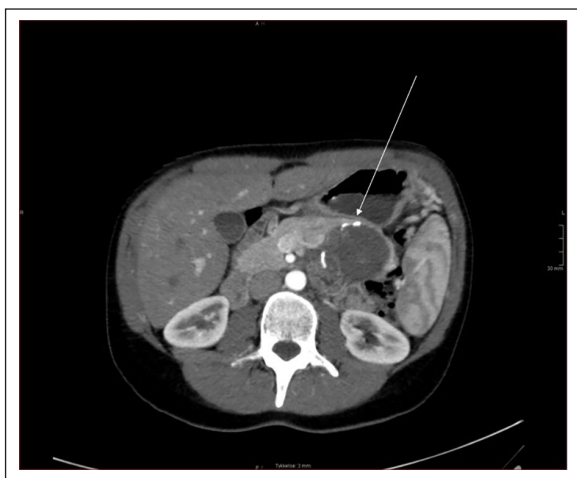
A 30-year old woman with a solid pseudopapillary neoplasm of the pancreas. Axial contrast-enhanced arterial phase CT image shows a well-defined heterogenous mass in the tail of the pancreas with peripheral calcifications (arrow).
